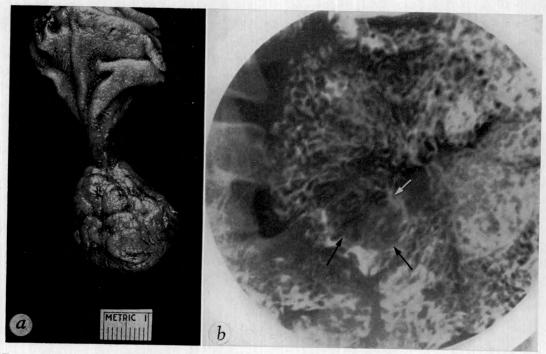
Adenomatous polyp of jejunum. (a) Photograph of polyp and small portion of wall of jejunum after removal. (b) Spot roentgenogram showing intraluminal defect caused by polyp (arrows).
